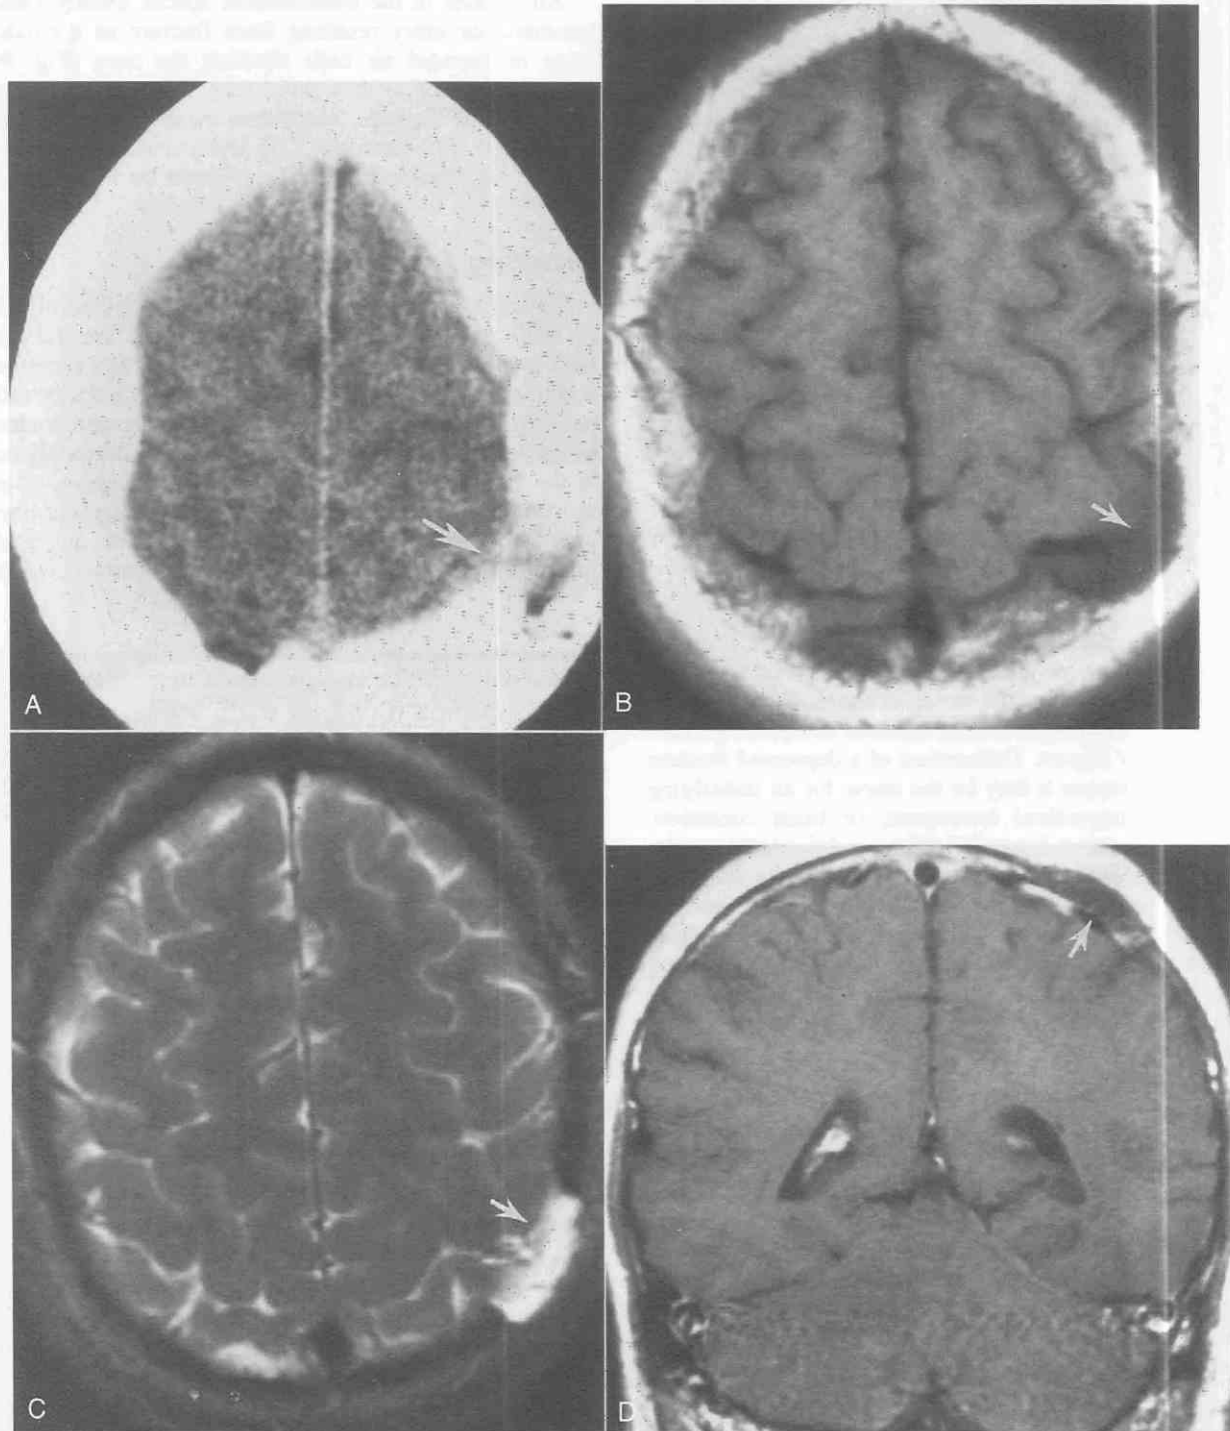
A, Growing fracture. Unenhanced CT can shows a defect in the left parietal bone (arrow). B and C, Axial T1-weighted (500/15) and T2-weighted (2500/80) MR images reveal mass isointense with CSF (arrows). D, Coronal enhanced T1-weighted (500/15) image shows no enhancement of lesion (arrow).
